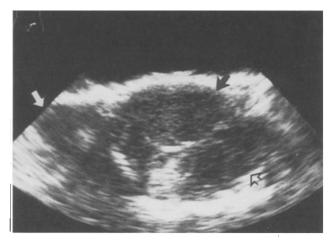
Ultrasound scan showing left testis (hollow arrow), abnormal mass (black arrow), and root of penis (white arrow).
